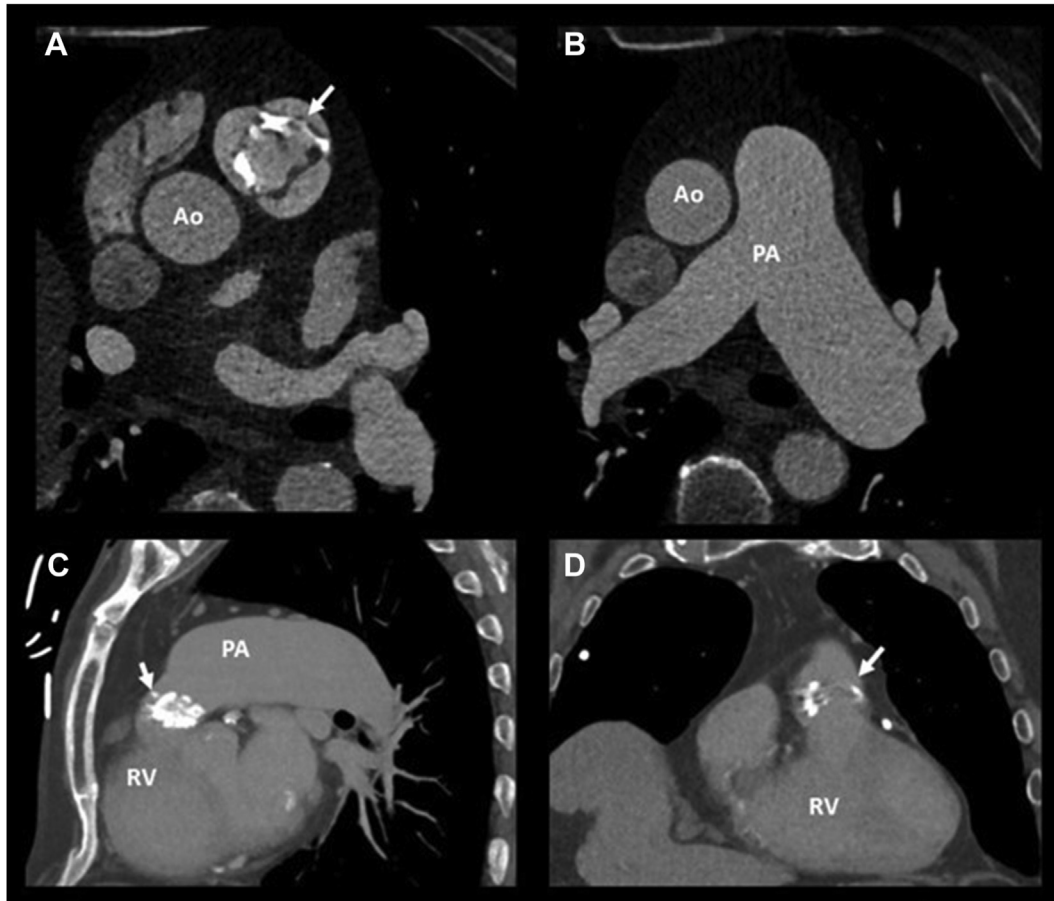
Contrast-enhanced CT of the chest. (A) Axial slice at the level of the PV (*white arrow*) showing valvular calcifications. (B) Axial slice at the level of the PA showing PA dilation. (C) Sagittal and (D) coronal sections demonstrating valvular calcifications (*white arrow*). Ao, Aorta.
